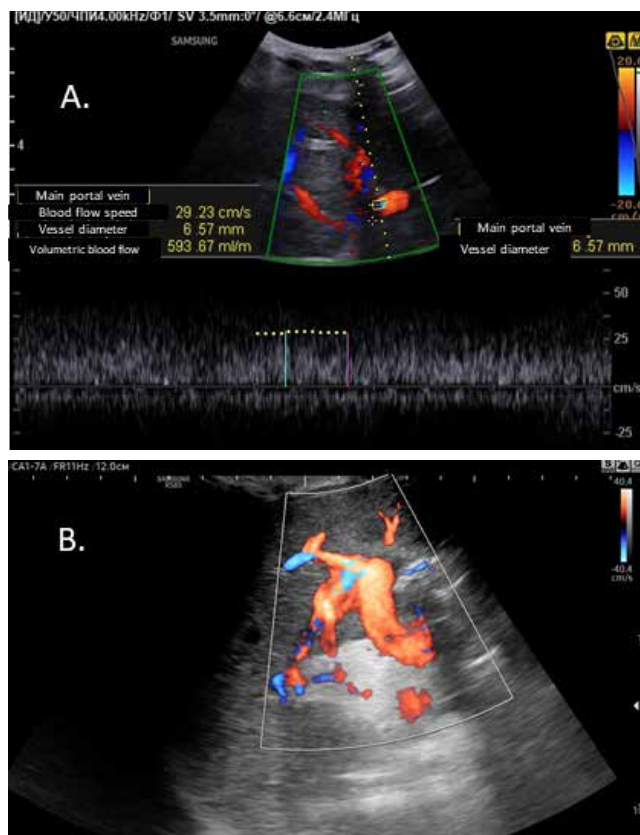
Doppler Ultrasound of Mesoportal shunts. Doppler US, Samsung RS80A-UA, convex transducer (mean frequencies 1–7 MHz). A: *Patient A.*, 1 month after mesoportal shunting. Volumetric blood flow in newly formed portal vein (internal jugular vein graft) is assessed satisfactory, up to 593 vk/minute; B: *Patient G.*, 12 months after mesoportal shunting. Mesoportal shunt is visualized all length throughout well, without filling defects or narrowings, the direction of the flow is hepatopetal
